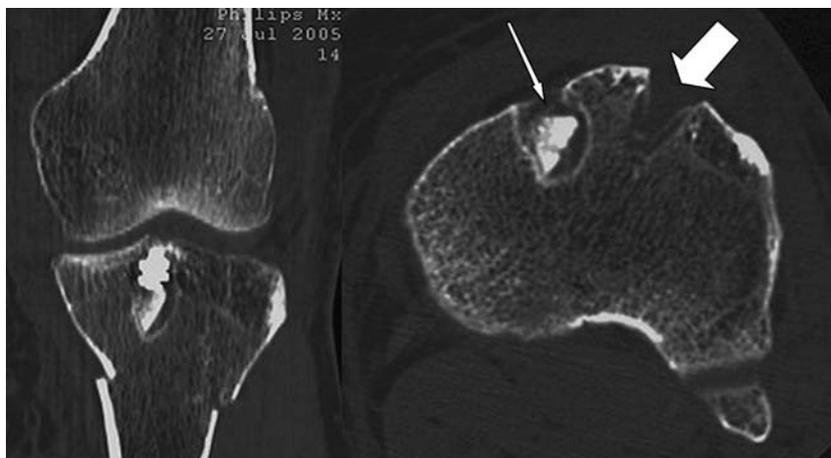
Coronal and axial CT images of the proximal tibia. Notice on the axial image that the fracture through the donor site (*thick arrow*) does not violate the tibial tunnel (*thin arrow*)
